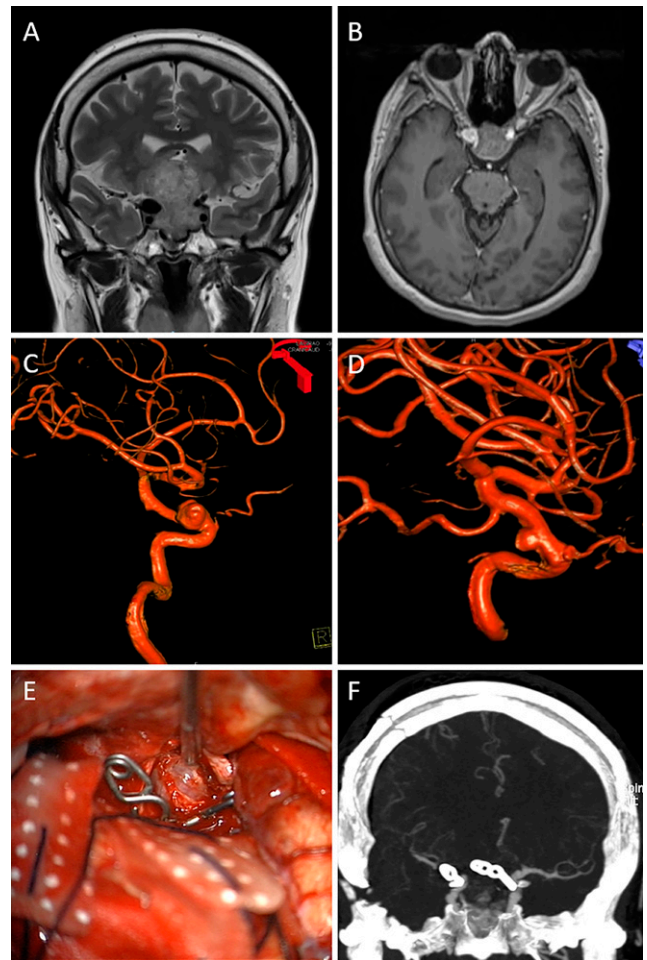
A: T2-weighted coronal MRI with the presence of a heterogeneous lesion in the sellar and suprasellar regions, it has defined borders, a bilobed appearance, and it dorsally displaces the third ventricle. It extends mainly into the cavernous sinus on the left side without surpassing the lateral tangent of the supra and intracavernous carotids. Increased thickness of the right supracavernous carotid. (Knosp 2, Hardy Wilson IIIC). B: Contrast T1 coronal MRI with a lesion in the sellar region that heterogeneously captures the contrast medium with hyperintense signal in the bilateral carotid portion with an increase in size predominantly on the right side. C: 3D reconstruction of angiography of the right upper lateral dome ICA. D: 3D reconstruction of angiography of the left ICA ventral medial dome. E: Transsurgical image of clipping of paraclinoid aneurysms and resection of sellar lesion. F: Coronal section tomography angiography with the presence of clips with adequate bilateral aneurysmal exclusion. 3D = three-dimensional.
